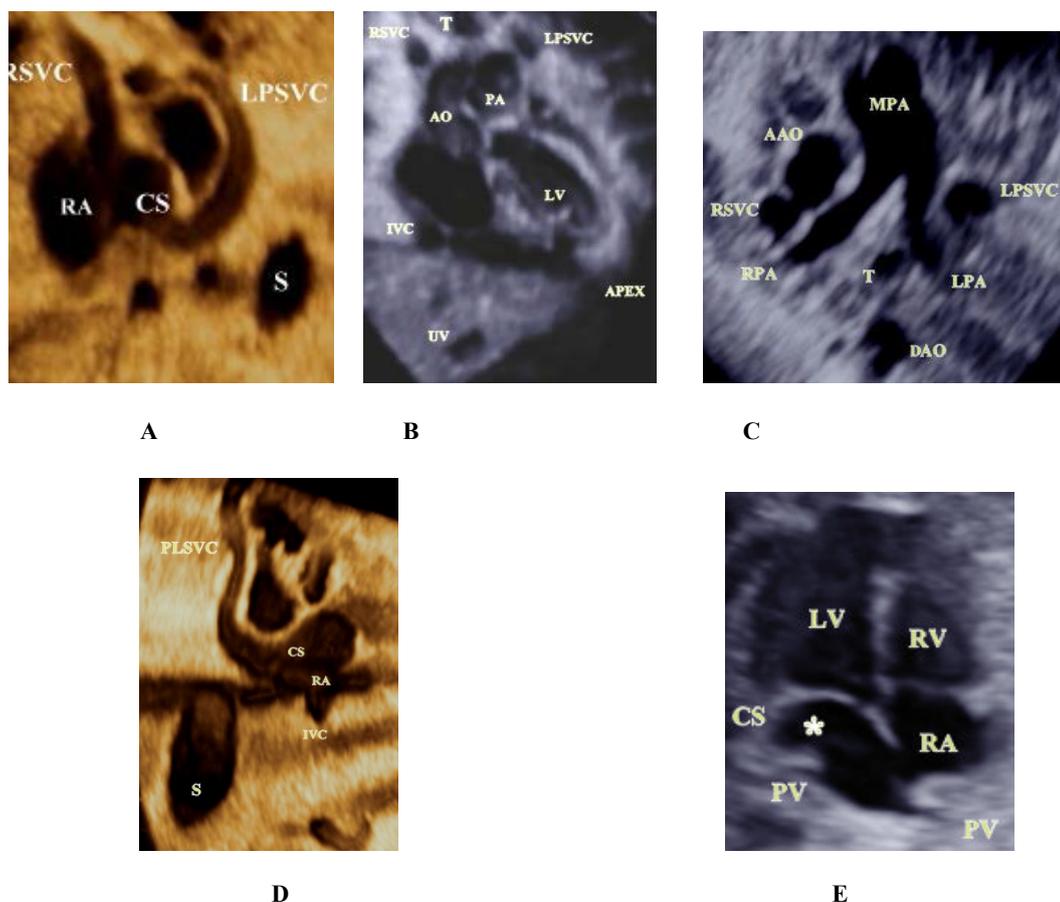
Volume-rendered images A, B, C: showing 2 superior vena cava, one on the right and the other on the left side. D-Oblique parasagittal ultrasound image of the patent left superior vena cava (LSVC), the dilated coronary sinus (CS) and the right atrium (RA). E-4 chamber view showing dilated coronary sinus (star).
